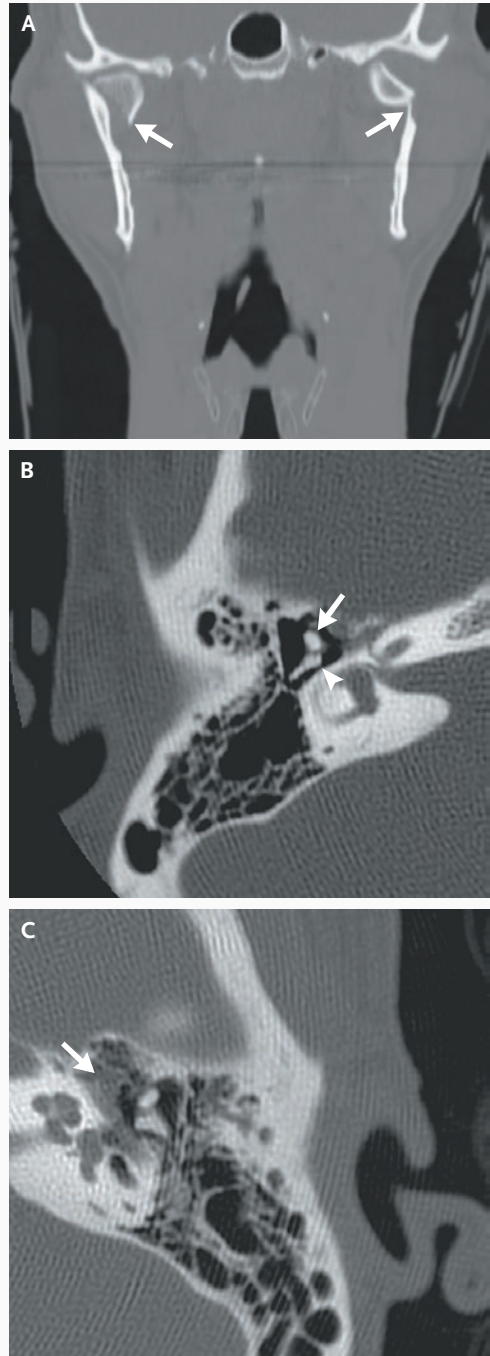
Computed Tomographic Scan of the Mandible and Temporal Bones in the Patient.
